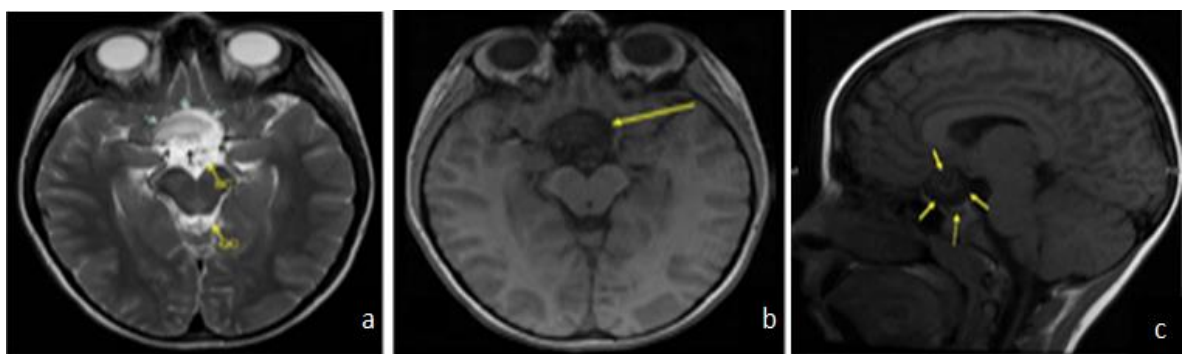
T2 and T1-weighted MR Brain images of a patient in axial (a, b) and sagittal (c) planes respectively
